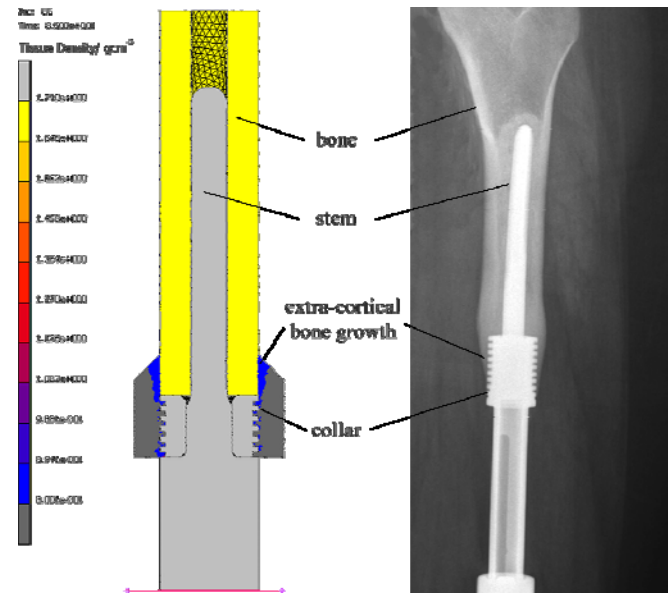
Left: Predicted bone growth (blue) with elastic modulus of approximately 2 GPa around an implanted grooved collar (light grey) and cortical bone shaft (yellow). Right: Good correspondence with X-ray results taken 12 years after implant insertion, where there was adventitious bone formation and good osteointegration with the HA-coated collar.
